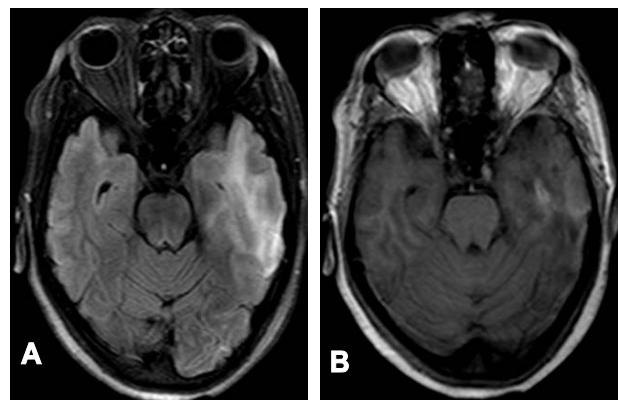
(A) FLAIR image shows hyperintensity in left temporal lobe. Subtle signal changes are also seen in right temporal lobe. (B) T1-weighted image showing hyperintensity in left temporal lobe suggestive of subacute hemorrhage.
